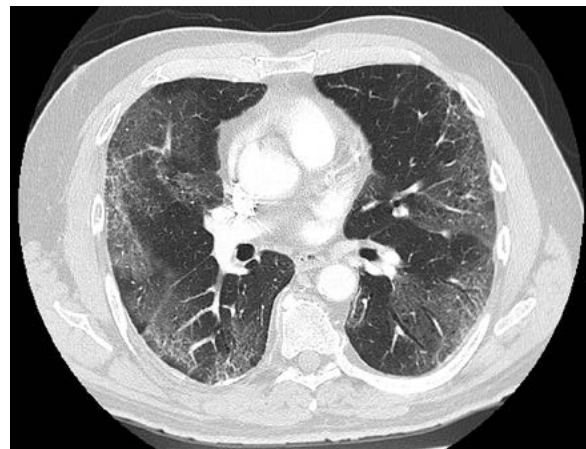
Chest CT at time of presentation (COVID-19 1/18/2021, CT 1/22/2021)
